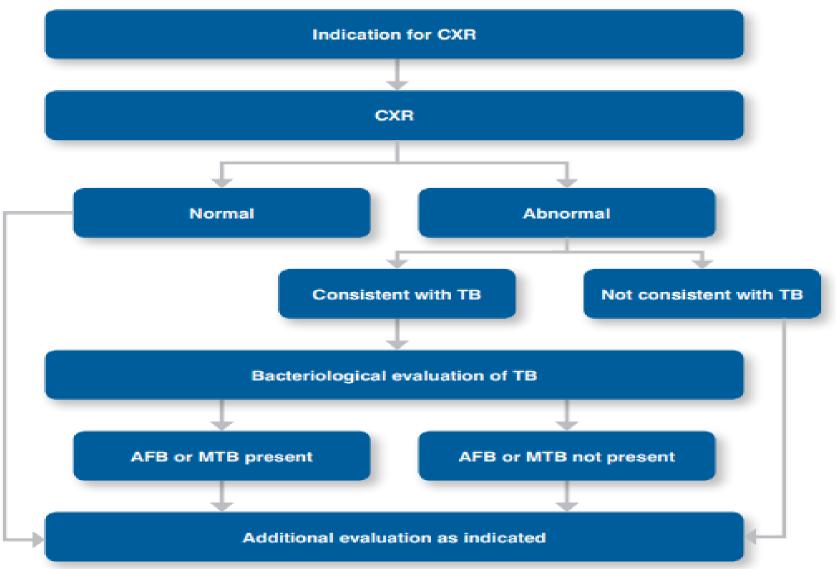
Using chest radiography as a triage tool
